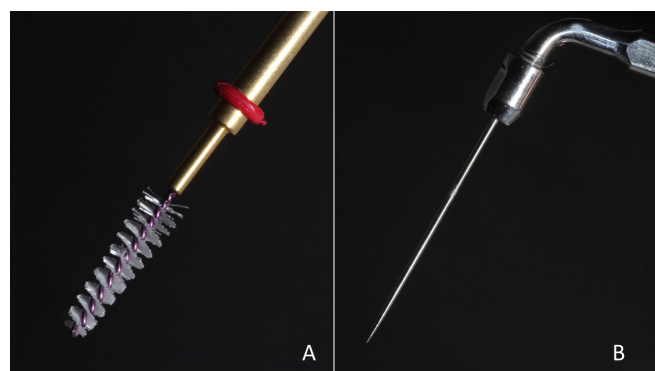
(A): Root canal cleaning brush. (B): The ultrasonic tip.
